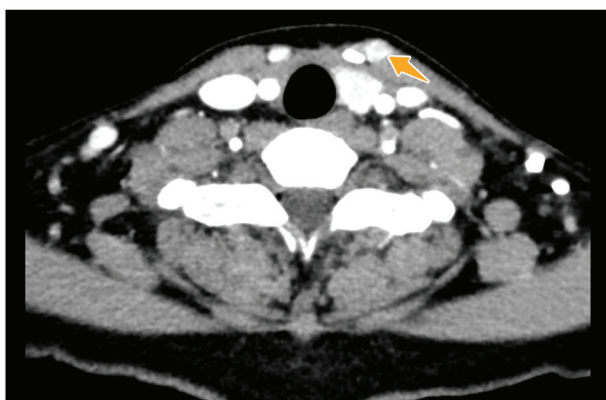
Computed tomography scan of the smaller skin metastasis of papillary thyroid carcinoma (orange arrow).
